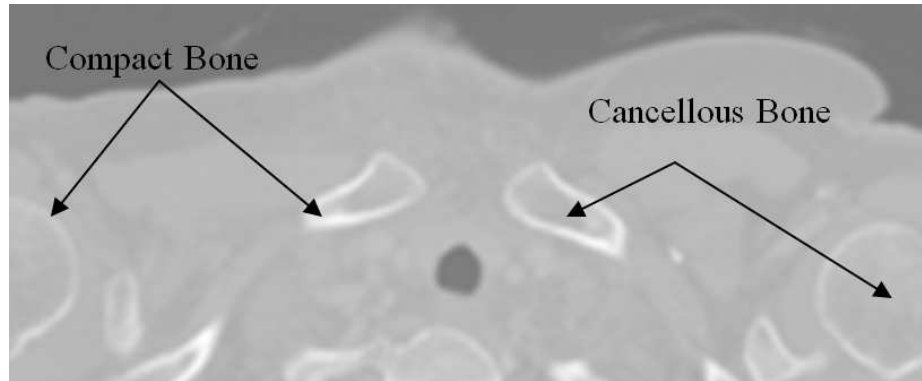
Zoomed abdominal section of a CT volume. Note differences in compact bone with cancellous bone in the different bone structures.
